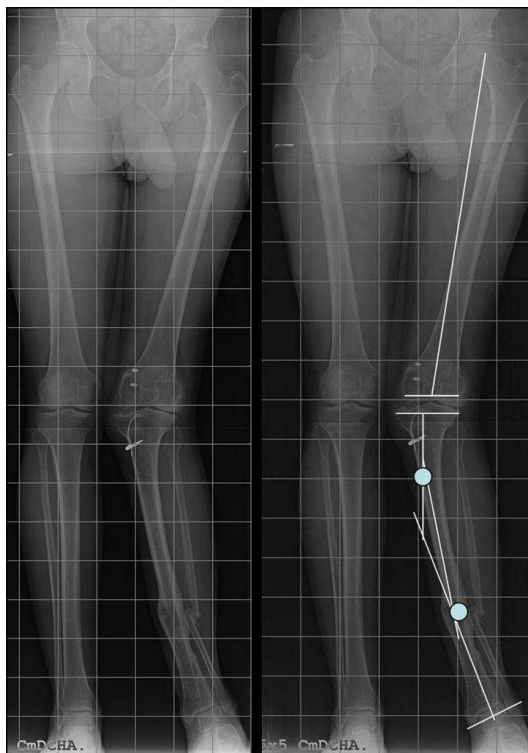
Full-length standing AP radiograph of both lower extremities including the hip, knee, and ankle. Osteotomy Planning Using the Anatomic Method described by Paley
